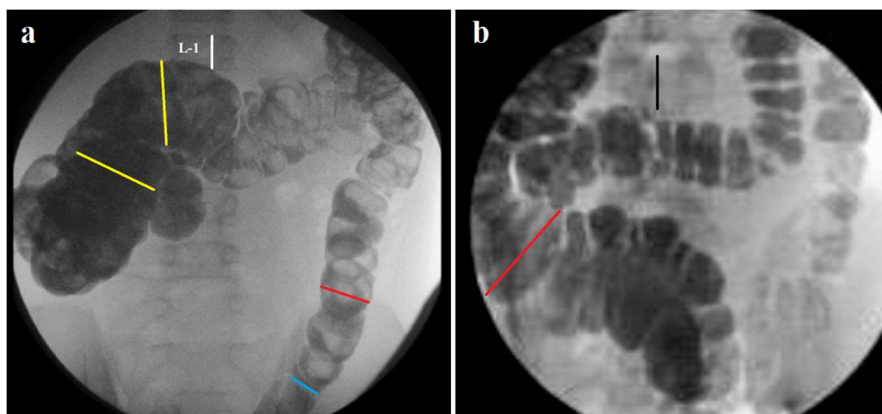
Radiographs from the peer-reviewed article. (a) (Figure 1) with the caption "Contrast enema shows dilated right and narrow left colon". The patient's age is not known. His sigmoid colon was removed, but the diagnosis is not specified in the article. The cecum is superimposed on the ascending and right side of the transverse colon. Knowing that in children 15 years of age, the L-1 body height is 2.2 cm, we calculated the approximate width of the ascending intestine (yellow line - 6 cm). The descending colon without gaustrations looks like a rosary. It consists of successive segments 3.3 cm wide (red line) with gaps between them 2.2 cm wide (blue line) (norm 2.5-3.2 cm). (b) In Figure 2, with the caption "Five representative contrast enemas showing dilated right and narrow, spastic left", the right half of the colon is visible in only one X-ray (b). Its width is 4.6 cm (norm 5.28 ± 0.32 cm). The descending colon contracted after partial emptying. In the remaining 4 cases, the right half of the large intestine is not visible. They have obvious symptoms of colitis.
